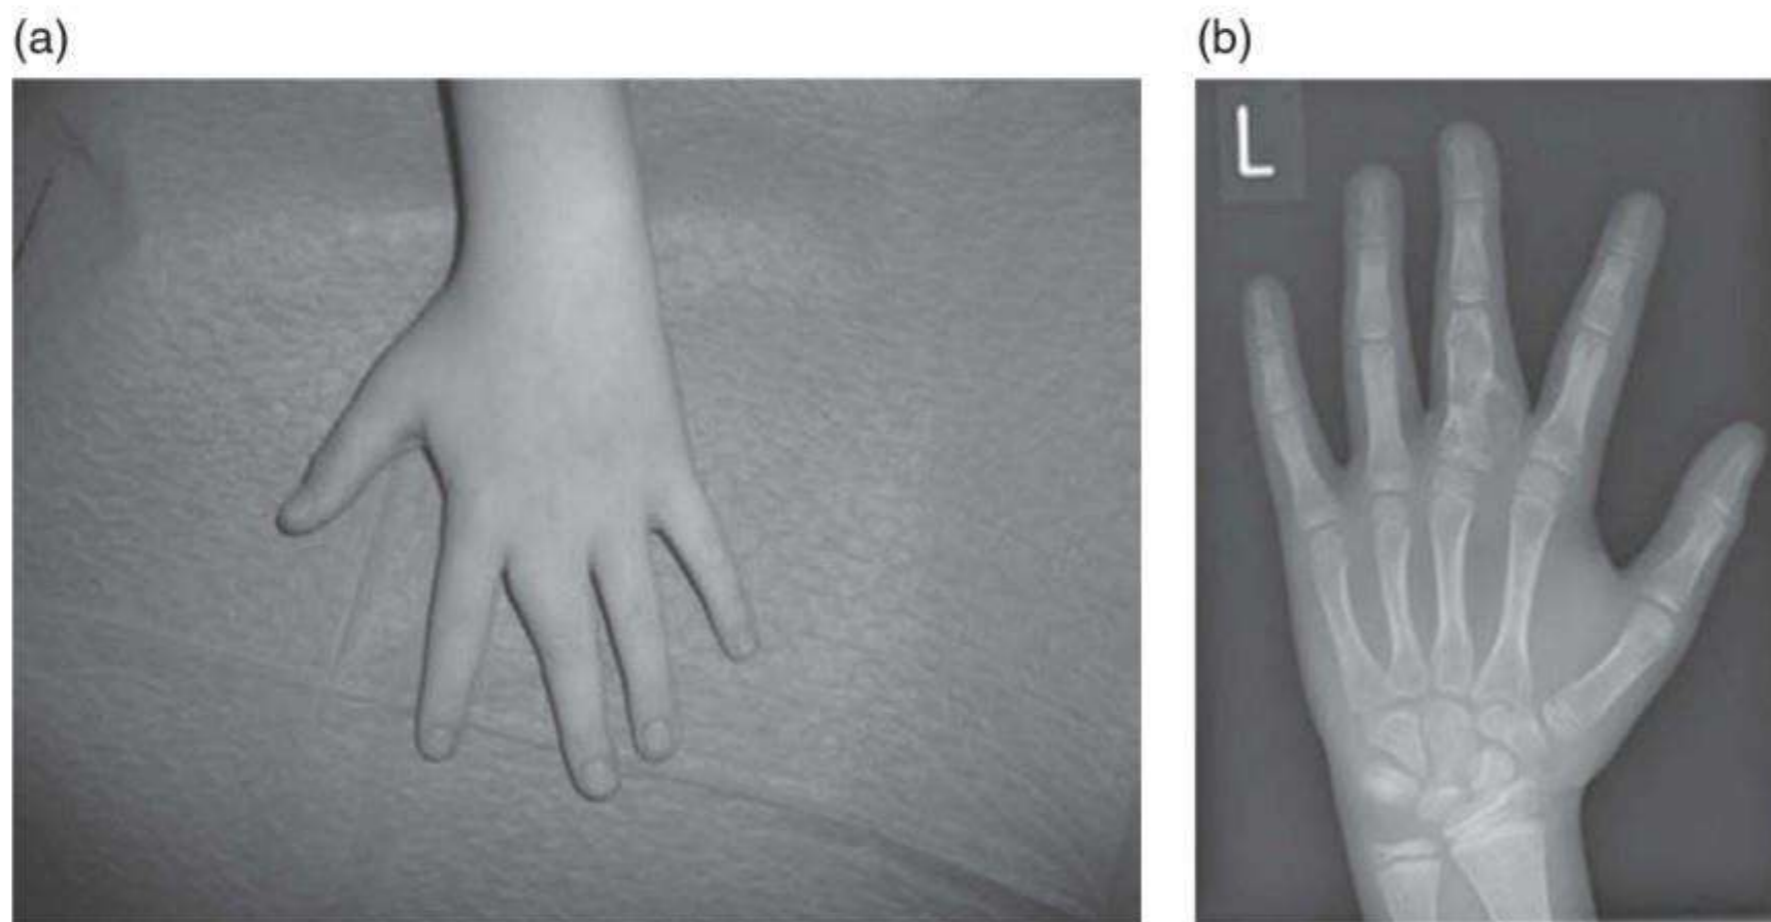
Clinical picture of an 11-year-old's hand. 11.2b Radiograph of the child's hand.
